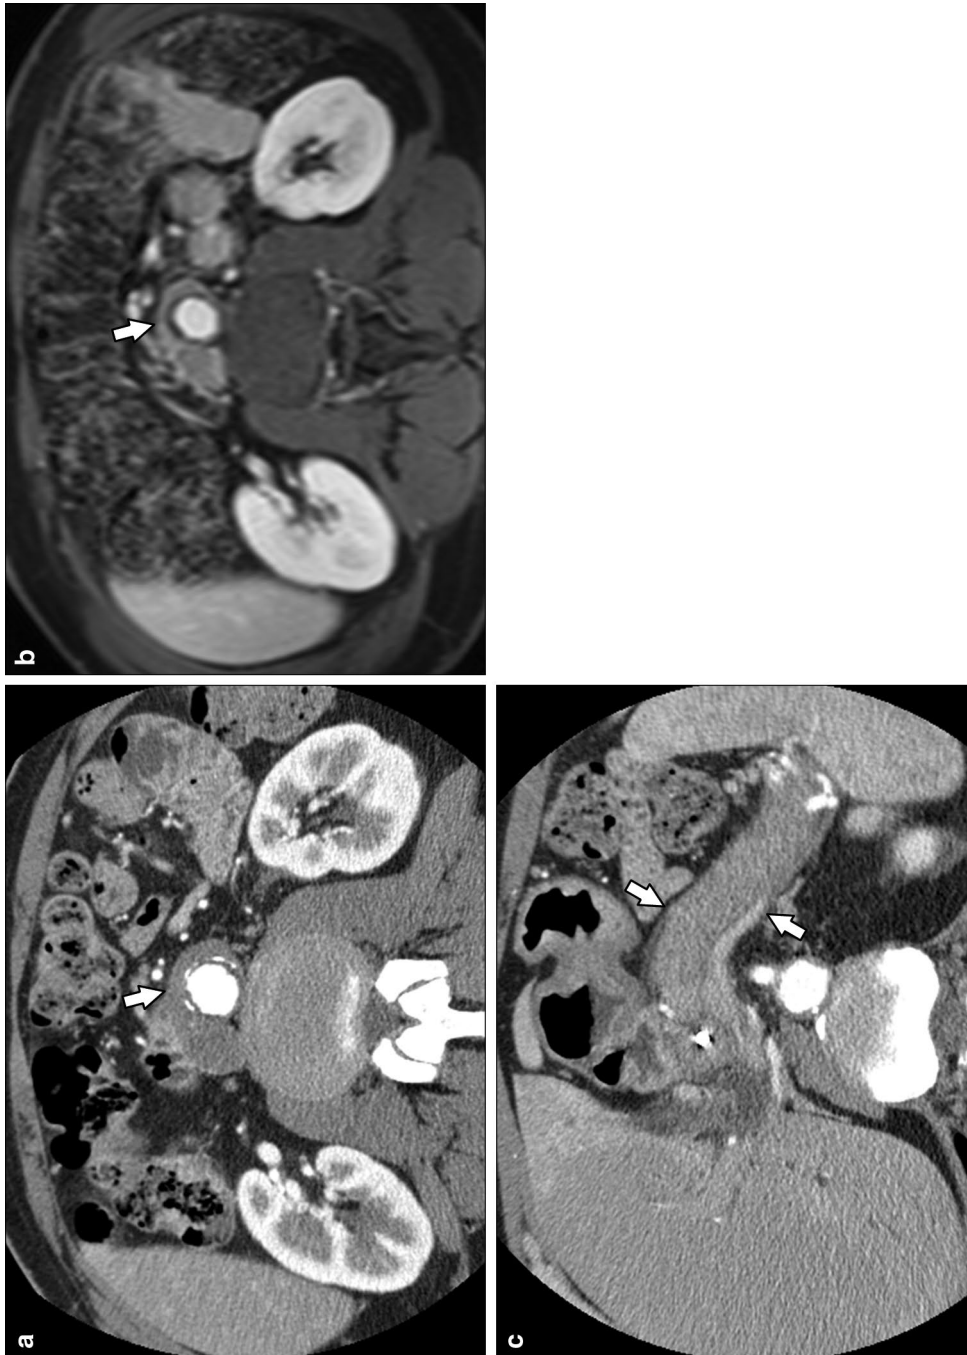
A 62-year-old male with a history of common bile duct stent placement. a Axial contrast-enhanced CT and b T1 FS contrast-enhanced MR images show circumferential soft tissue surrounding the aorta (arrow) compatible with retroperitoneal fibrosis associated with autoimmune pancreatitis. c Axial contrast-enhanced CT image shows a diffusely enlarged, homogeneously enhancing pancreas with hypodense rim (arrows). After a trial of corticosteroid treatment, the patient's imaging findings resolved which suggested autoimmune pancreatitis
